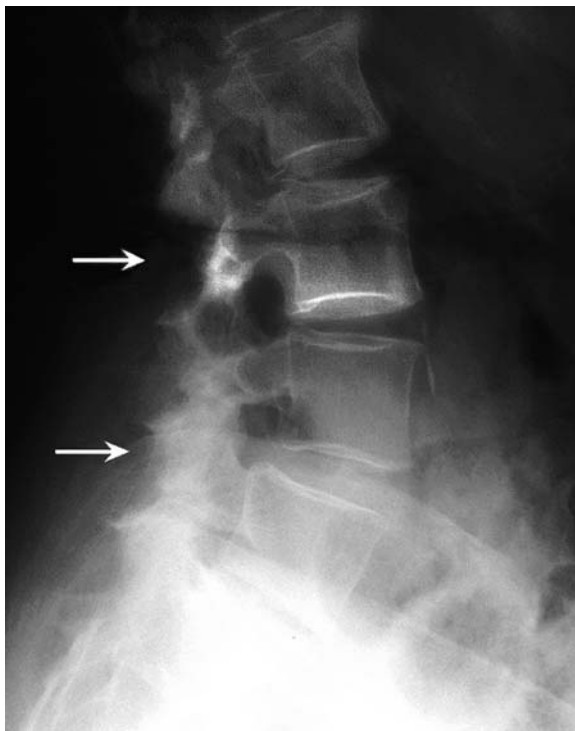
A lateral lumbar spine X-ray of the patient whose bone density study is shown in Fig. 2-17. The *arrows* indicate sclerotic regions in the posterior elements.
